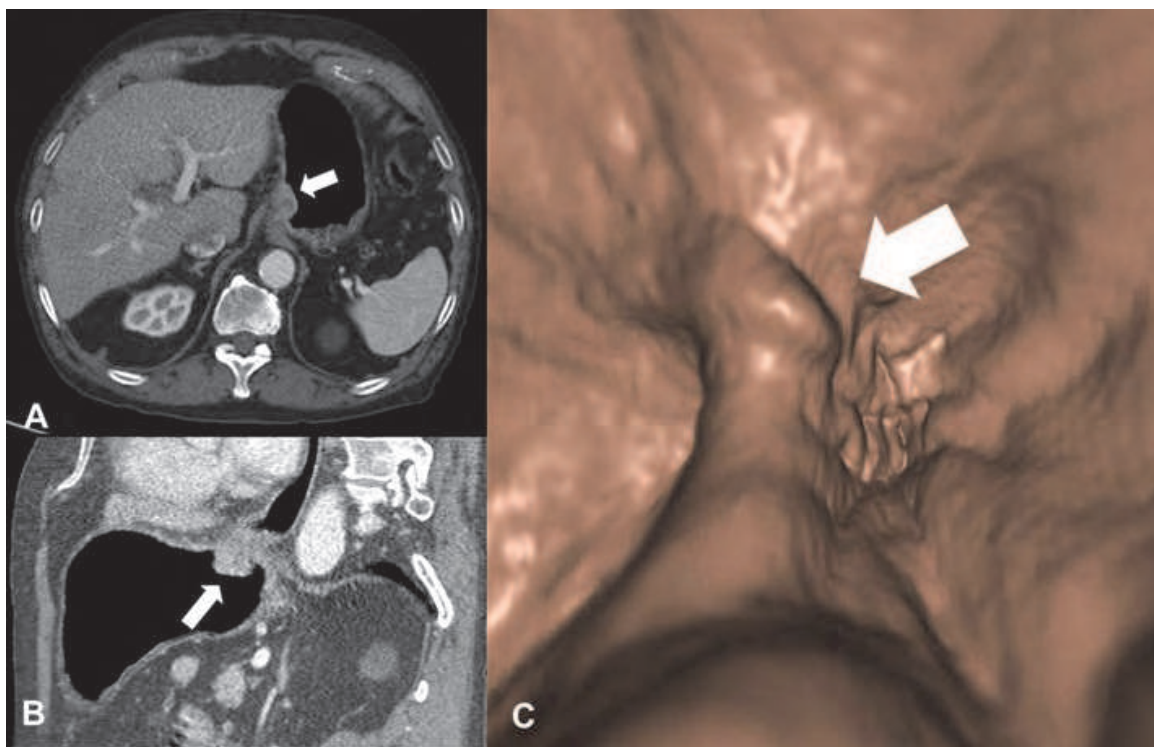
Gastric carcinoma. A. CT transverse scan. B. CT multi-planar reconstruction on sagittal plane. C. Tri-dimensional virtual gastroscopy. The tumor appears as an irregular wall thickening protruding within gastric lumen and affecting the proximal tract of the stomach (arrows). Stomach has been distended by air.
